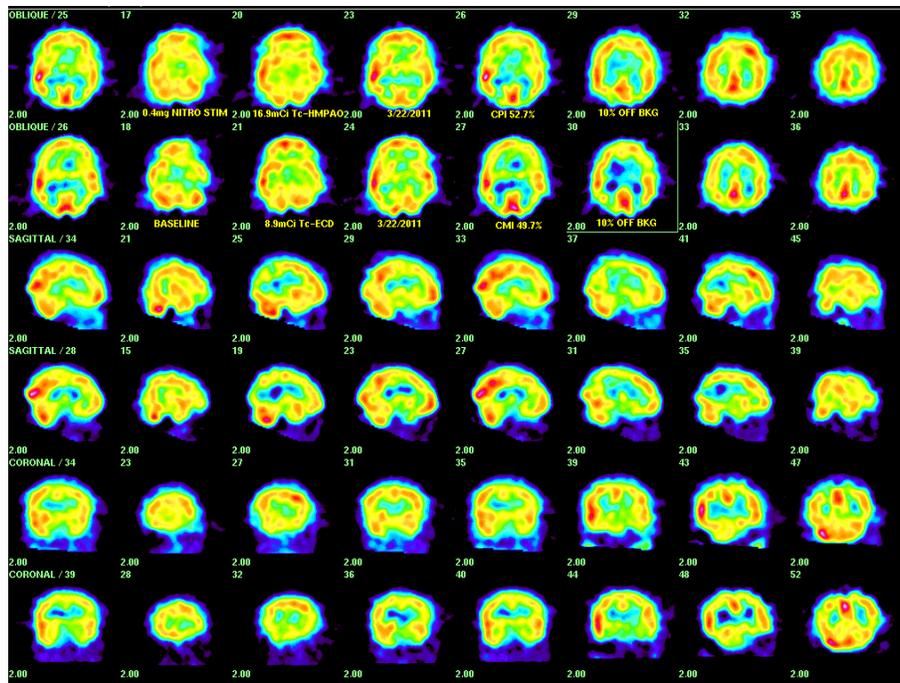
The same, now 46 year-old woman whose brain SPECT was shown above (Fig. 6a) is involved in a more serious motor vehicle accident (combined impact speed > 50 miles/hr) and although she does not recall losing consciousness, suffers acceleration-deceleration traumatic brain injury (TBI) accompanied by a post concussion syndrome, with exacerbation of migraine headache, difficulty concentrating and lightheadedness. She also has even more difficulty with controlling her weight and often gains several pounds within a week. Although TBI patients often show abnormality more prominently in perfusion-stimulated brain SPECT, this patient's basal study (bottom row of 3 paired image rows to the right) shows more prominent basal ganglia abnormality, patchy temporal deficits, bilateral posterior parietal and patchy periventricular hypoperfusion. Her renal function at the time of the follow-up study is normal. Use of Tc-99m-ECD, which more closely mirrors F-18 fludeoxyglucose determined cerebral metabolism, for the follow-up basal study may also have enhanced recognition of subtle metabolic abnormalities. Initial evaluation of pituitary function in this patient was normal, although in the present series of patients with neurological complaints, 46/107 or 43.0% of TBI patients had at least one abnormal (inappropriate) pituitary hormone level.
